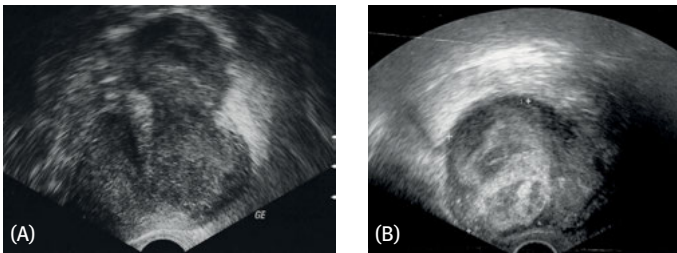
Sonographic findings in PEComa. (A) A tumor with heterogeneous echogenicity that is predominantly hypoechoic containing hyperechoic as well as virtually anechoic spaces of varying size. Interestingly, pathologists diagnosed this tumor to be cellular leiomyoma at the time of primary diagnosis, as leiomyosarcoma at the time of initial recurrence, and finally as PEComa upon further relapse. The irregularly contoured margins in sonography already made a leiomyoma rather unlikely; (B) heterogeneous, predominantly hyperechoic tumor. The margins between the areas of differing echogenicity are partly irregular, which is strongly suggestive of an irregular mesenchymal tumor.
